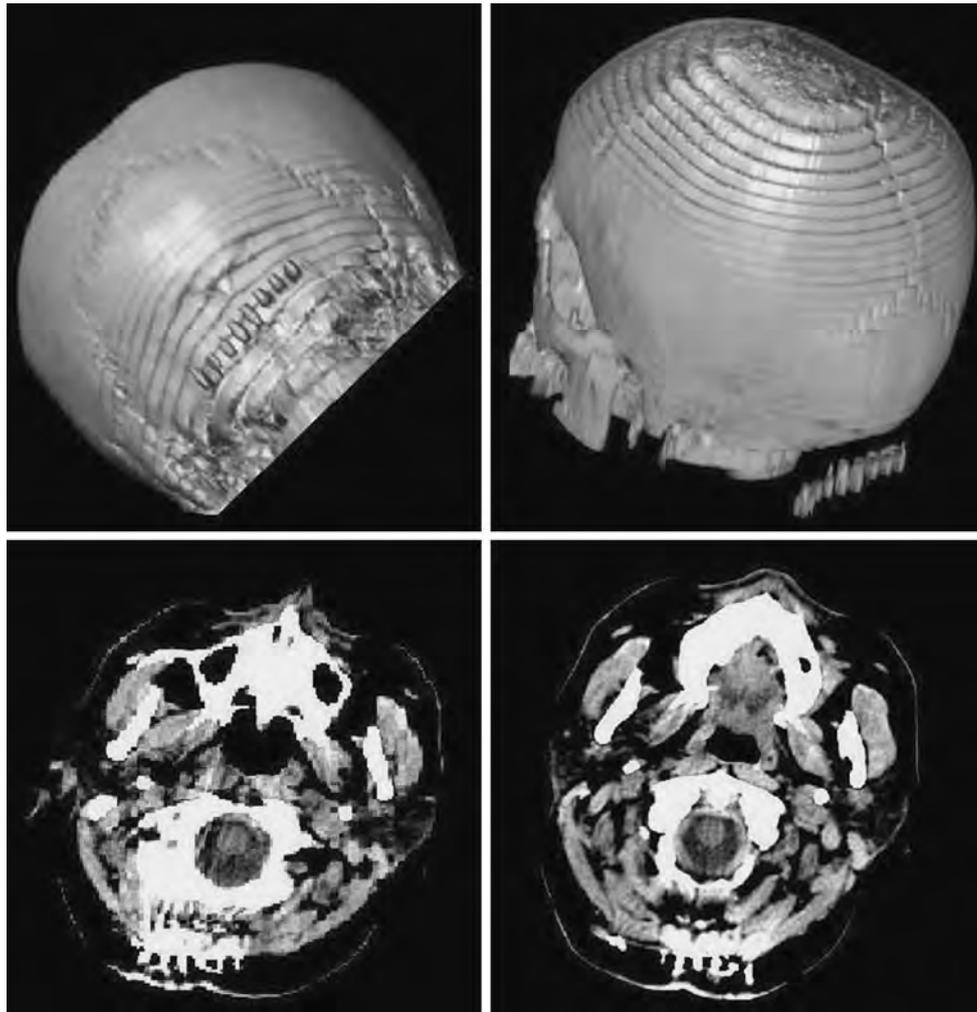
Post-operative three-dimensional reconstruction CT image (*upper part*) of a patient comprised in our series, submitted to occipital nerve stimulation for refractory cluster headache; as it is
